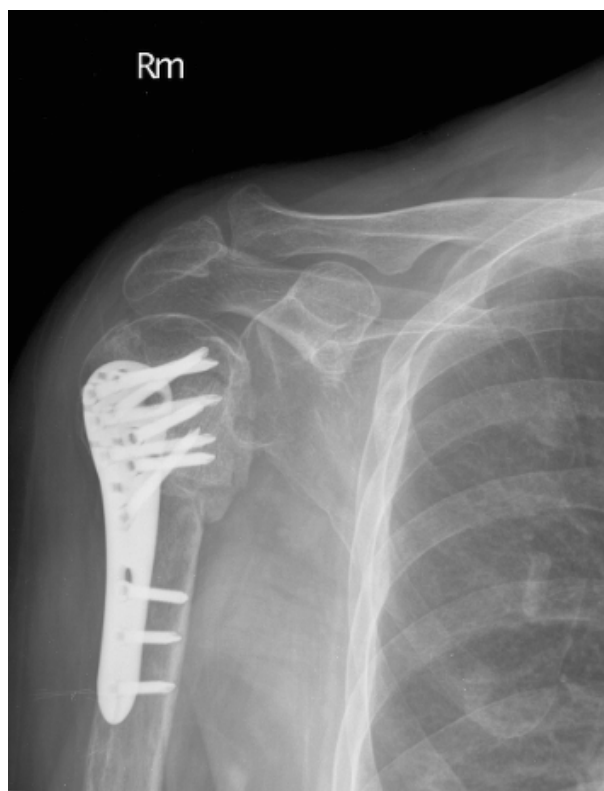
Anteroposterior right shoulder radiograph taken at 5 months showing complete bony union.
